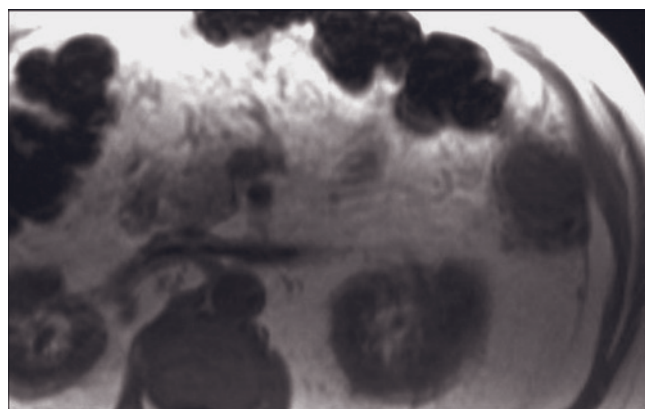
Peritoneal seeding: thin platelike, small nodular, large nodular patterns and advanced disease. Fat-suppressed T1-weighted postgadolinium SGE images (*a, b*) in a patient with ovarian cancer demonstrate platelike peritoneal metastasis (arrowheads, *a, b*). Fat-suppressed T1-weighted postgadolinium SGE images (*c, d, e*) in a second patient with ovarian cancer demonstrates small nodular pattern of peritoneal seeding (arrows, *c, d, e*). T2-weighted fat-suppressed SS-ETSE (*f*), T1-weighted
